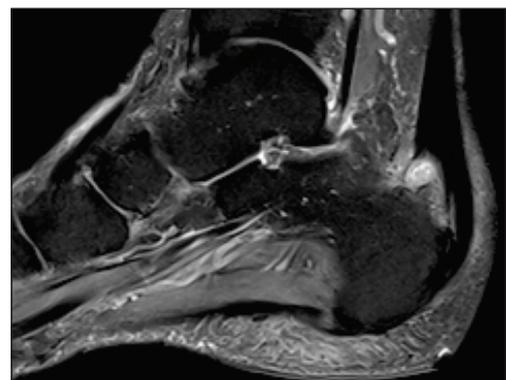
MRI shows degenerative changes at the insertion of the achilles tendon as well as bone edema at the impingement area.
